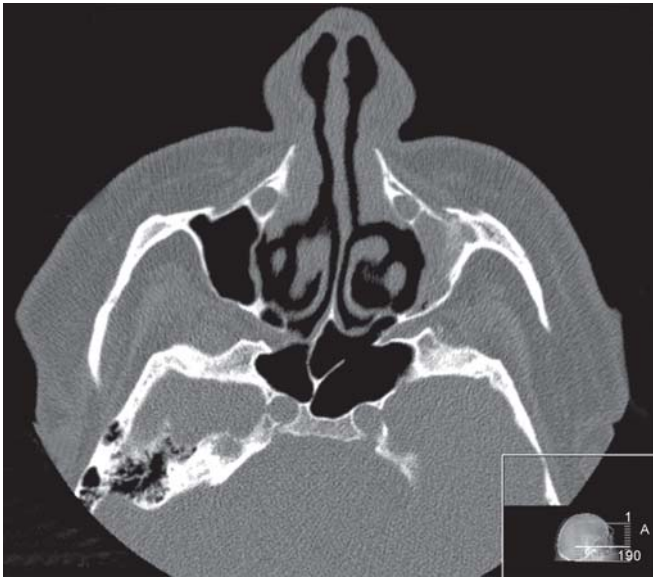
Axial section of CT paranasal sinuses showing consolidation and contraction left maxillary sinus, and reduced antral volume
